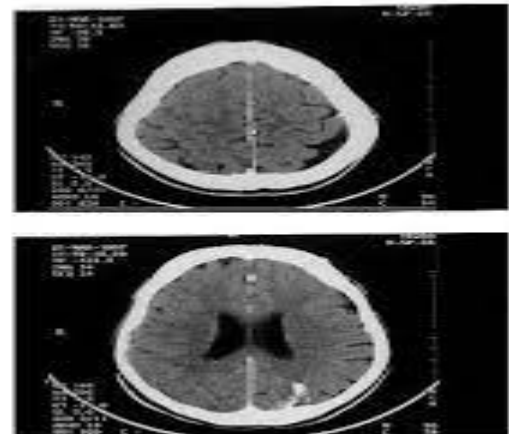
CT: Calcifications and leptomeningeal temporo-occipital hemangioma
